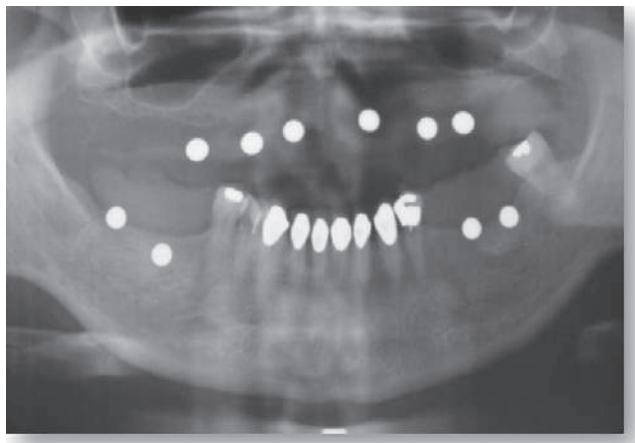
A panoramic radiograph showing the ball bearings positioned intraorally with a wax or resin baseplate.
